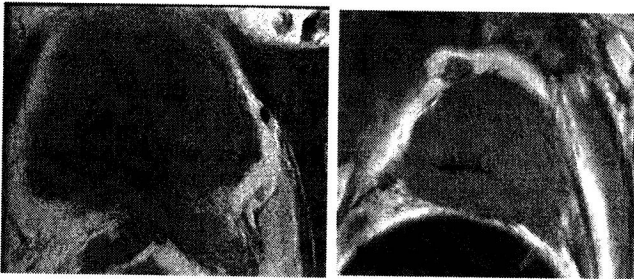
Comparison of image of prostate at 1.5 Tesla (a, left) and 3.0 Tesla (right). Note the improved SNR of the latter due to the increased field strength. The same T1-weighted spin-echo sequence was used for both
